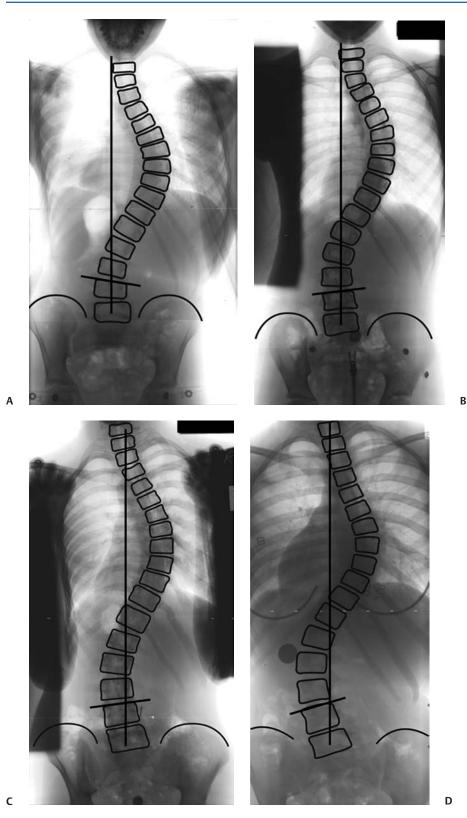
Radiographic PA images with outlined vertebral bodies, CSVL, and L4 tilt for (A) a Lenke type 1AR curve (L4 tilts to the right); (B) a Lenke type 1 AL curve (L4 tilts to the left); (C) a Lenke type 1B curve; and (D) a Lenke type 1C curve.
